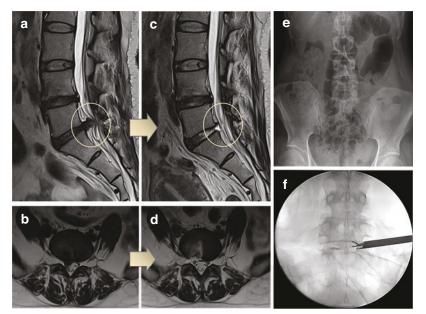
TELD for huge central lumbar disc herniation. A 30-yearold female patient presented with right leg radiating pain. MRI showed huge central disc herniation at the L4-5 level (a). TELD was performed under local anesthesia. Successful removal of herniated disc was achieved (b), and her symptoms recovered immediately after the procedure
